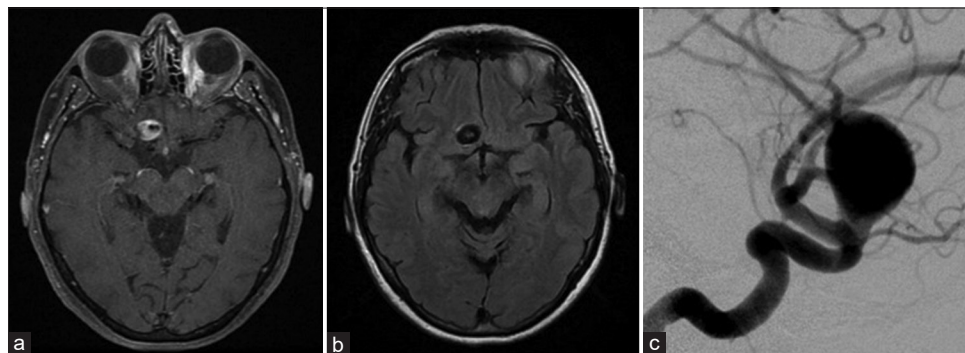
Diagnosis of the aneurysm. (a and b) Axial magnetic resonance image with and without paramagnetic contrast, respectively, showing an aneurysm in the anterior circulation measuring 16 mm × 13 mm × 12 mm. (c) Digital subtraction angiography, lateral view, confirming the presence of a giant ophthalmic segment aneurysm with a wide neck (5.5 mm), measuring 17 mm × 14 mm
